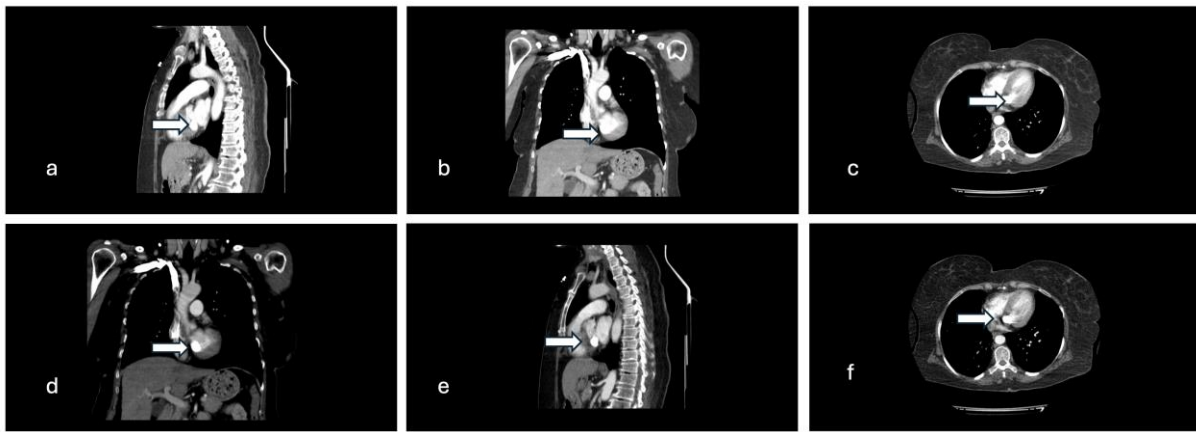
Different views of the atrial myxoma located in the left atrium as seen on CT images: a, e) Sagittal view of the atrial myxoma, b, d) Coronal view of the atrial myxoma, c, f) Axial view of the atrial myxoma indicated by white arrows.
